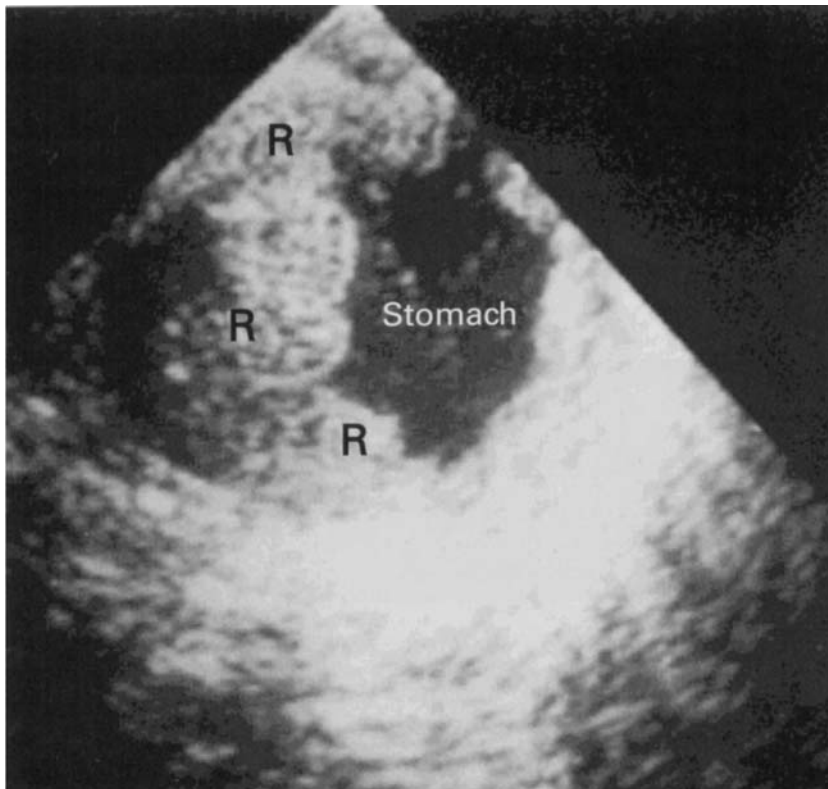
Hiatal hernia. Stomach or bowel can herniate into the thorax and become interposed between the normal oesophagus and the heart. Rugal folds (R) within the stomach can be mistaken for a tumour or mass. The heart can be obscured from visualisation, as in this example. (Reproduced from Seward *et al.* 1992,²⁰ by permission of the American Society of Echocardiography.)
